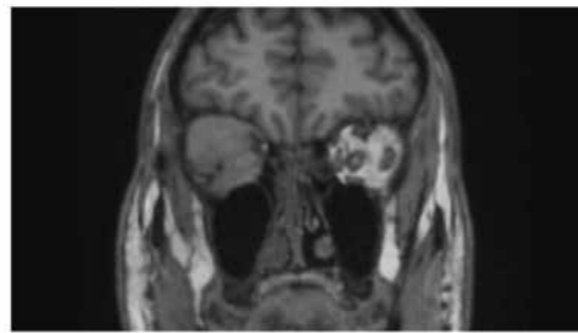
Coronal T1-weighted MRI showing loss of right orbital apex structures due to mass lesion.
